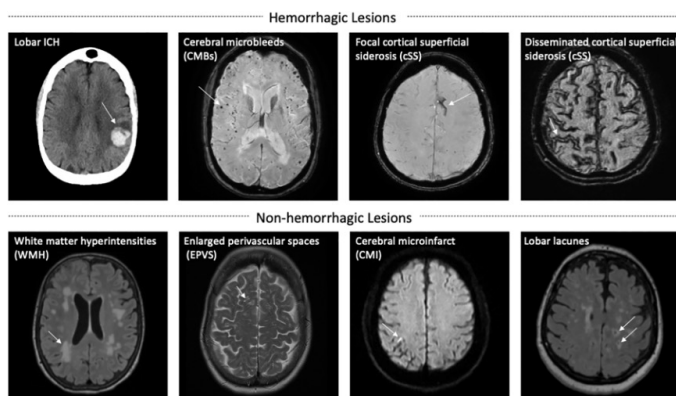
Cerebral microbleeds and superficial siderosis can be observed with gradient echo and susceptibility-weighted MRI sequences.
